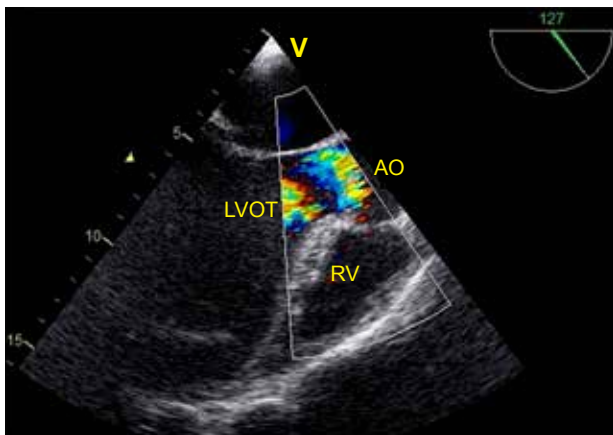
Postoperative echocardiography image. Ao – aorta; LVOT – left ventricular outflow tract; RV – right ventricle.
